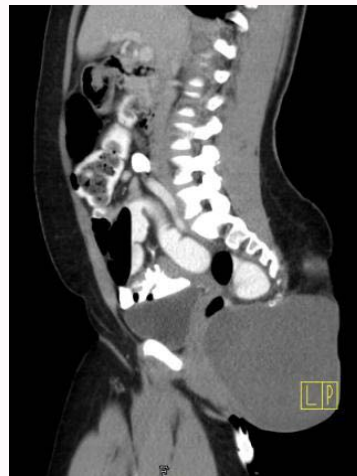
CT scan of the abdomen and pelvis showing large cystic mass measuring 12.6 m × 15.2 cm × 12.2 cm arising from the posterior rectal region and extending into the midline gluteal fold.
